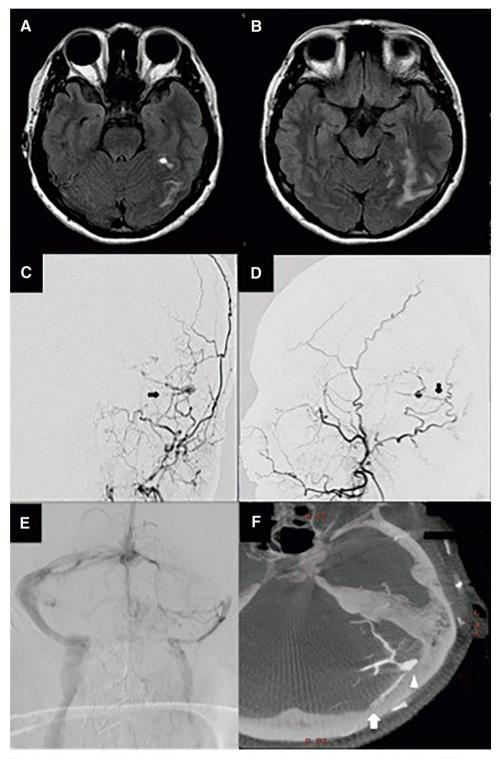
A 49-year-old, right-handed female presented to our hospital with motor aphasia. (A and B) Images obtained with MRI–FLAIR showing high-intensity area in the left temporal and occipital lobes involving a small hemorrhage. (C and D) Anterior-posterior and lateral views of left ECA angiogram showing the arteriovenous fistula shunting at the left TS (black arrow), which is fed by OA mastoid branch and drained into the cortical veins retrogradely. (E) Anterior–posterior view of left VA angiogram showing the left TS occlusion. (F) Multiplanar reformation images of con-beamed CT obtained from left ECA 3D rotational angiography showing the shunting area at the middle part of the transvers sinus (white arrow) and draining into the cortical veins retrogradely via lateral tentorial sinus (white arrowhead). ECA: external carotid artery; OA: occipital artery; TS: transverse sinus; VA: vertebral artery
